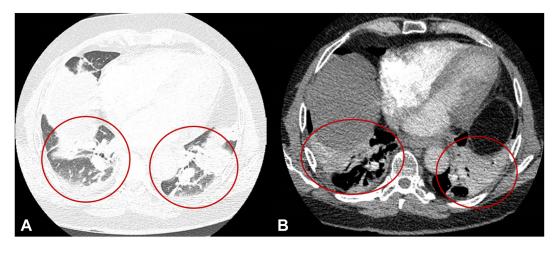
Chest CT image (A) and abdominal CT image (B) showing pleural effusion and atelectasis.
